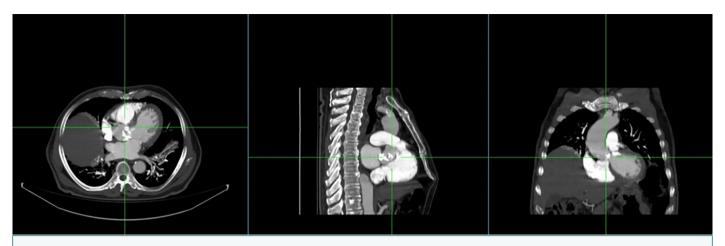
Contrast-enhanced thoracic computed tomography demonstrating severe calcification of the aortic valve with extension toward the interventricular septum. Multiplanar reconstructions (axial, sagittal, and coronal views) show calcific infiltration from the aortic root into adjacent cardiac structures, raising the possibility of conduction system involvement due to proximity to the His bundle. These findings support the suspicion of a degenerative conduction disorder coexisting with severe aortic stenosis
